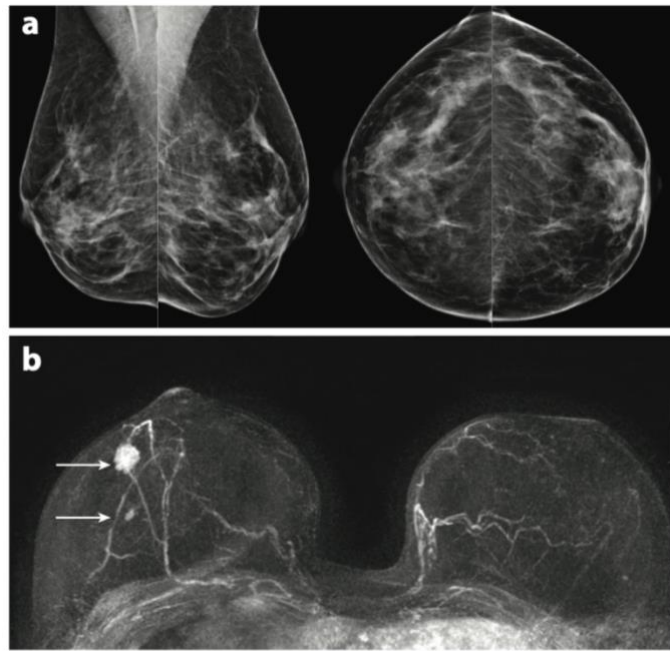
Example of a mammography-occult biologically aggressive cancer (a) two-view mammography with no evidence of breast cancer. (b) Two enhancing lesions present in an abbreviated MRI (biopsy proven-multifocal high grade HER 2-positive) (Kuhl et al., 2019).
